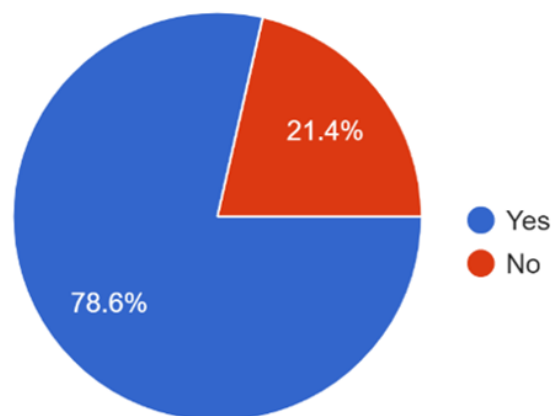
Depicts the percentage of respondents using intraoral digital radiography and conventional radiography
